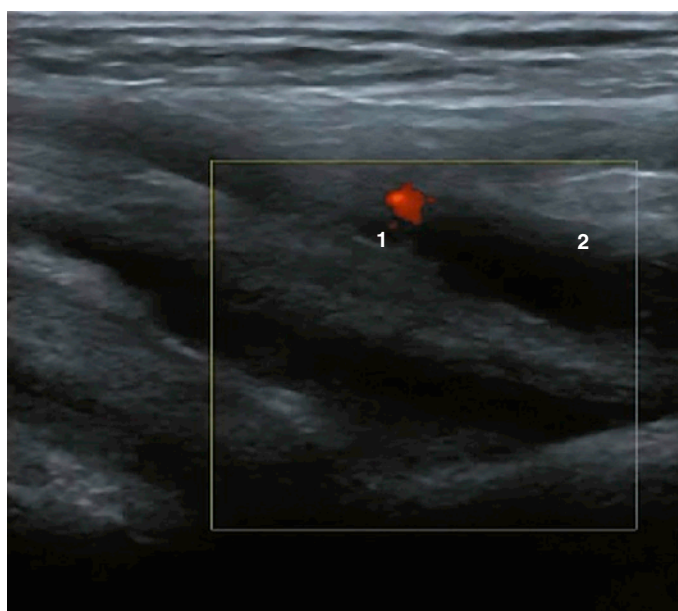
BICIPITORADIAL BURSITIS OF THE DISTAL BICEPS TENDON. Longitudinal and transverse (14 to 5 MHz) images of the distal biceps tendon (1) and proximal radius reveal enlargement of the bicipitoradial bursa (2) surrounding the tendon. The Doppler signal is positive within the bursa.
